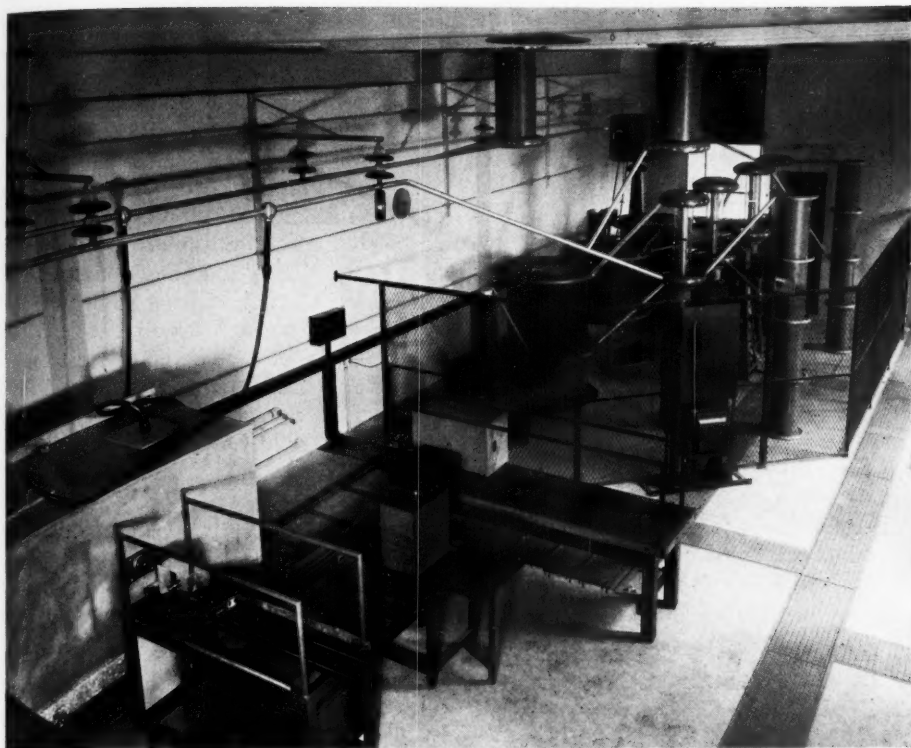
View of 400 kv. x-ray room.
